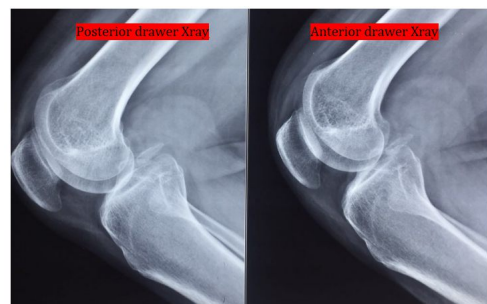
1 Preoperative Knee x-ray lateral view showing posterior tibial subluxation and avulsed fragment of PCL
